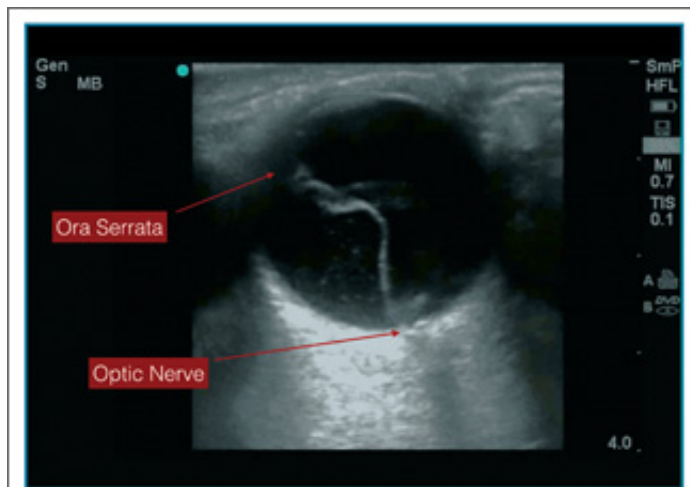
Ocular ultrasound showing a partial retinal detachment tethered at the ora serrata and optic disc.
